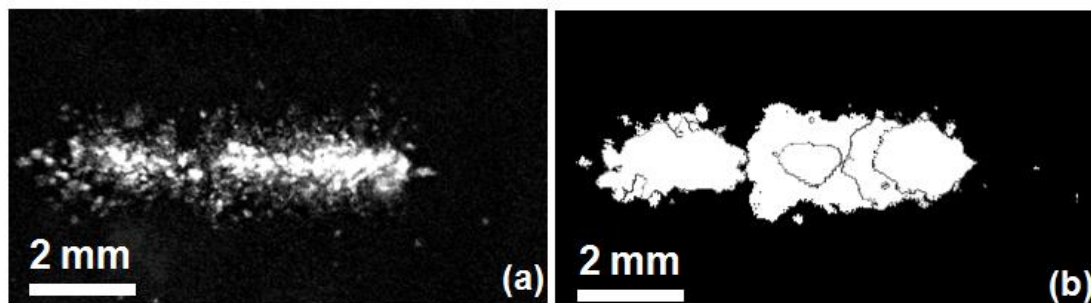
Image of a lesion generated from 3 single ultrasound pulses (a) and overlapping images of 3 bubble clouds taken from binary images (b). Ultrasound propagation was from left to right. Lesion damage matches the shape and location of the bubble clouds, although appears darker near the edges of the cloud.
